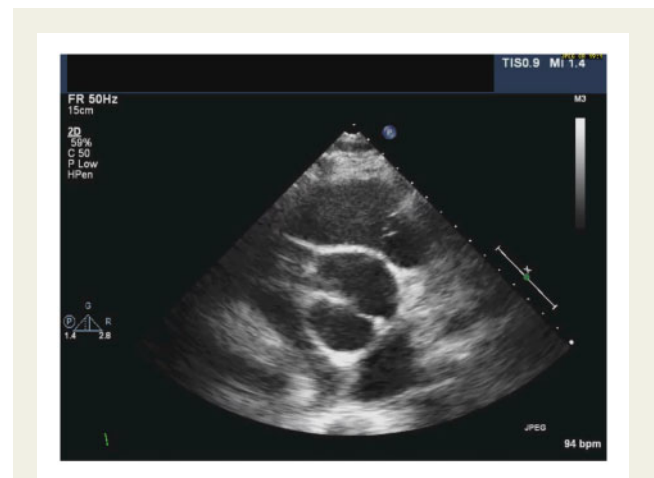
Transthoracic echocardiogram (short-axis view) showing a bicuspid aortic valve.
